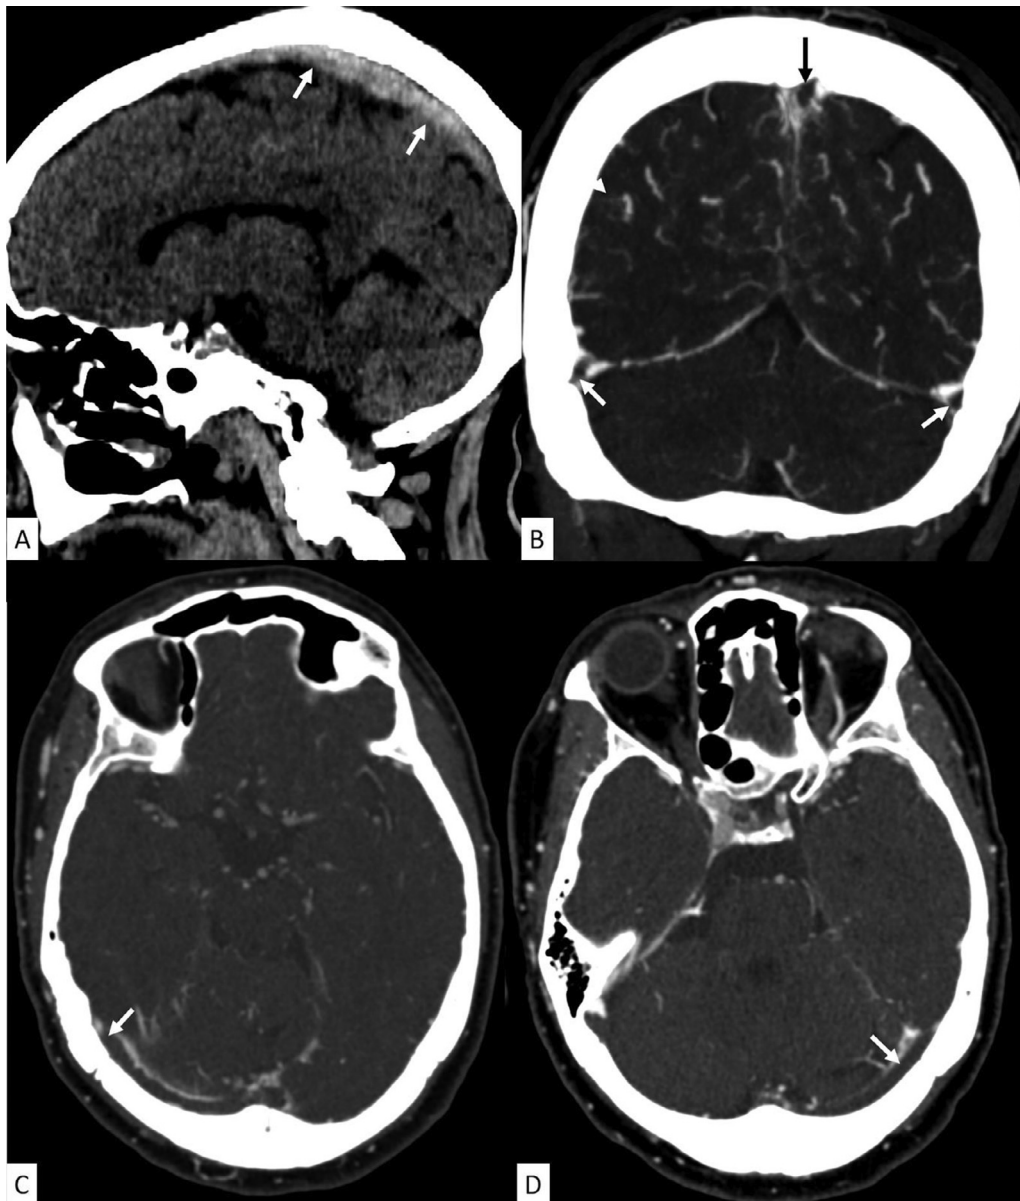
A 68-year-old woman presented with fever, cough, and shortness of breath. A nasopharyngeal swab RT-PCR test resulted positive for SARS-CoV-2. Three weeks later, she returned with generalized weakness, headache, nausea and vomiting. Sagittal CT brain without contrast (A) showing abnormally dense superior sagittal sinus (white arrows). Coronal (B) and axial (C, D) CT venogram showing filling defects within the superior sagittal sinus (black arrow, B) and the bilateral transverse sinuses (white arrows, A, B and C) consistent with venous thrombosis.
